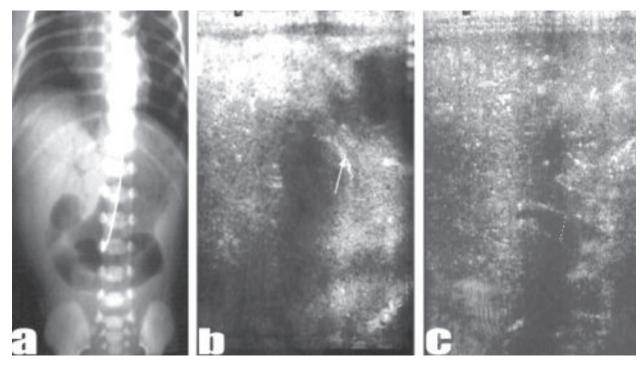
A case of late necrotizing interocolitis; a neonate ± 31 weeks, with congenital heart disease, formula feeding. (a) X-ray shows portal venous gas. (b) Sonogram shows thinning of intestinal wall (0.7 mm) with hyperechoic foci in the wall. (c) Sonogram shows air bubbles at portal vein branches. PV diameter = 0.22 mm.
